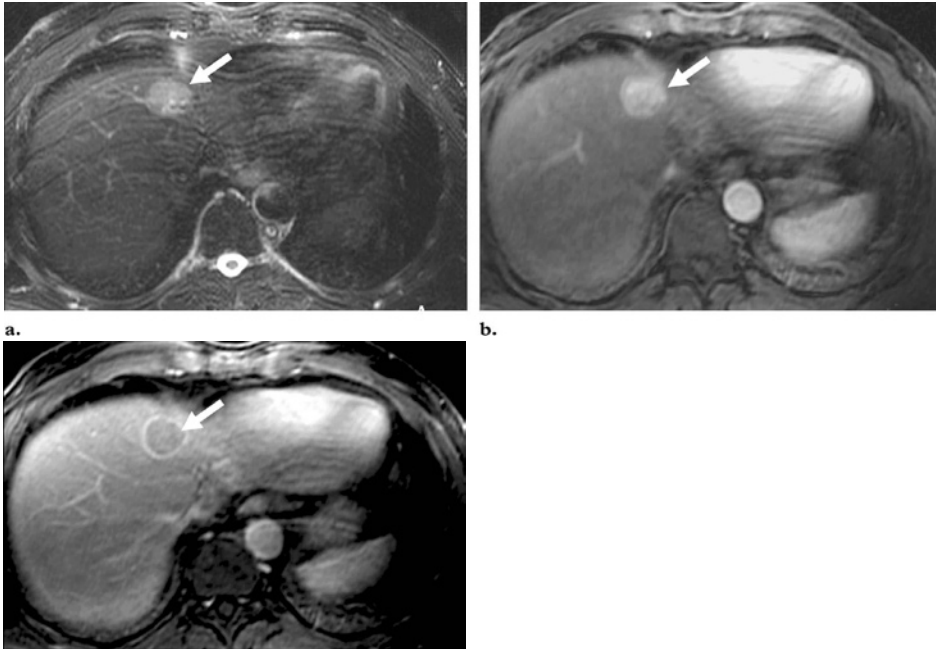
MR imaging appearance of an FNH lesion with a prominent pseudocapsule. a. Axial fat-saturated T2-weighted fast SE image shows a medium-sized FNH lesion (arrow) with a central scar, a pseudocapsule, and septa, all of which are prominent and have high signal intensity. b. Axial gadolinium-enhanced 3D GRE image obtained during the arterial phase shows intense homogeneous enhancement of the lesion (arrow), except for the central scar and septa. c. Axial gadolinium-enhanced 3D GRE image obtained during the delayed phase shows enhancement of the central scar as well as the pseudocapsule (arrow).
